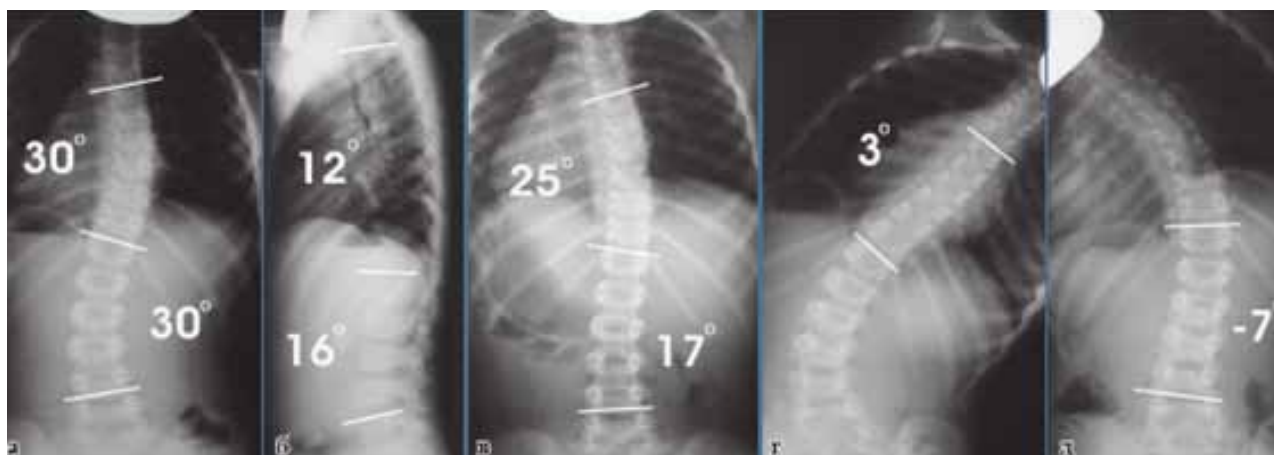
X-ray images of an idiopathic scoliosis patient requiring brace treatment: frontal image made in a standing position (a); lateral image made in as tan ding position (b); frontal image made in a lying position (c); frontal image made in a maximal right-side bending position (d); frontal image made in a maximal left-side bending position (e).
